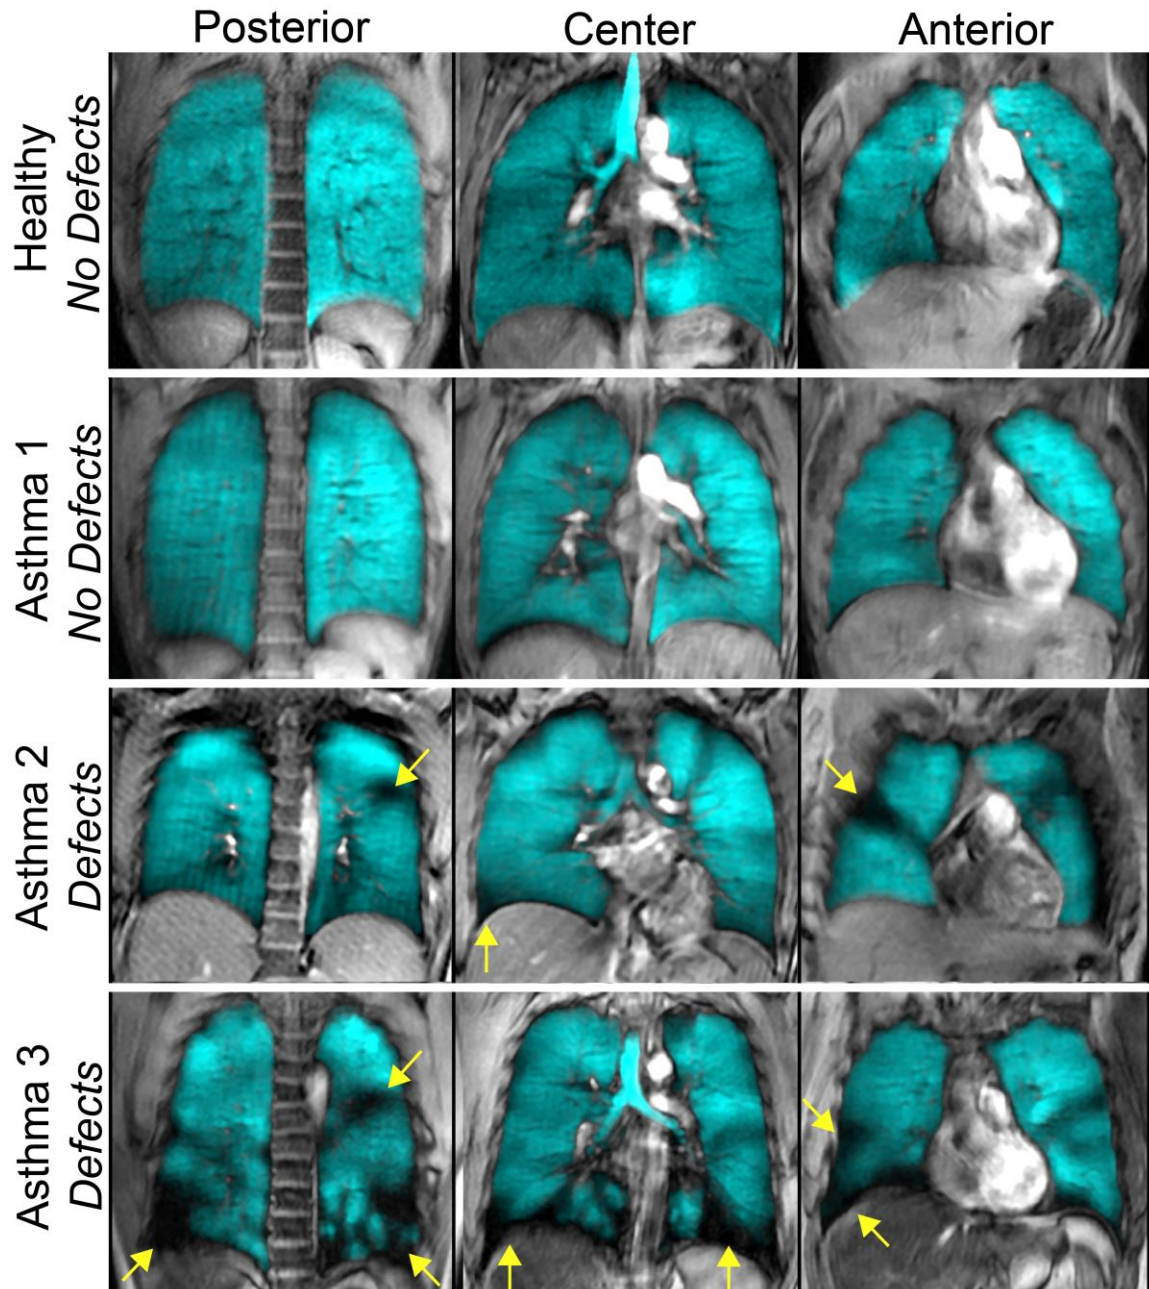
Hyperpolarized ^3He MRI of a representative healthy volunteer and asthmatic subjects.
